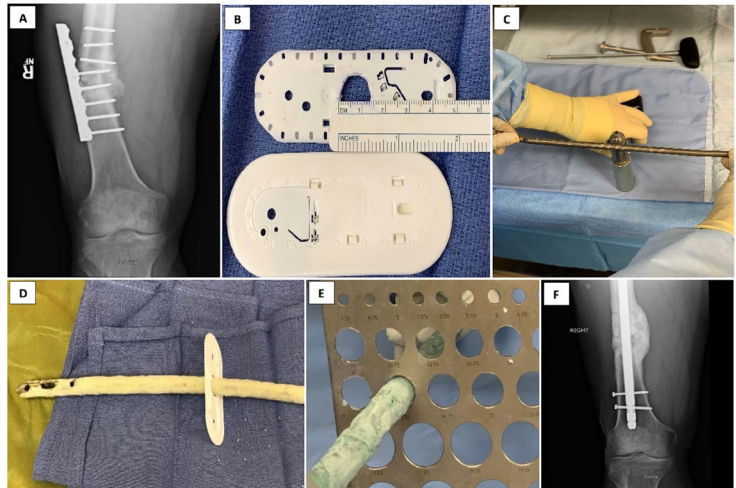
(a) AP femur radiograph demonstrating catastrophic hardware failure following treatment of *Streptococcus anginosus* osteomyelitis. Based on clinical and host factors, a single-stage large diameter antibiotic coated interlocking nail was selected. (b) A 12mm nail was selected after reaming to 15mm. A 14.5mm hole was then cut in the plastic portion of a suture packet to allow for an anticipated 1.5mm cement mantle. (c) The nail surface is roughened to increase bonding of the antibiotic laded polymethylmethacrylate. (d) The customized plastic sizing guide is used to assess final construct diameter to ensure the nail will pass through the reamed canal. (e) A comparison template (Zimmer Biomet, Warsaw, IN) can also be used to assess final desired construct diameter. (f) Final AP radiograph at 12 months demonstrating osseous union, no evidence of infection recurrence and no hardware related complications.
